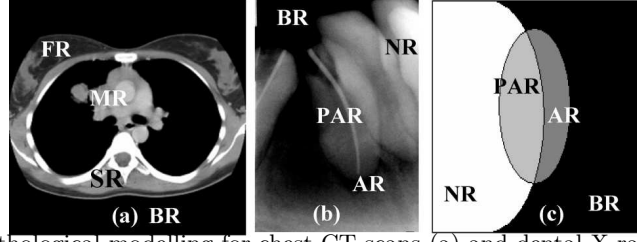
Pathological modelling for chest CT scans (a) and dental X-rays (b and c).
